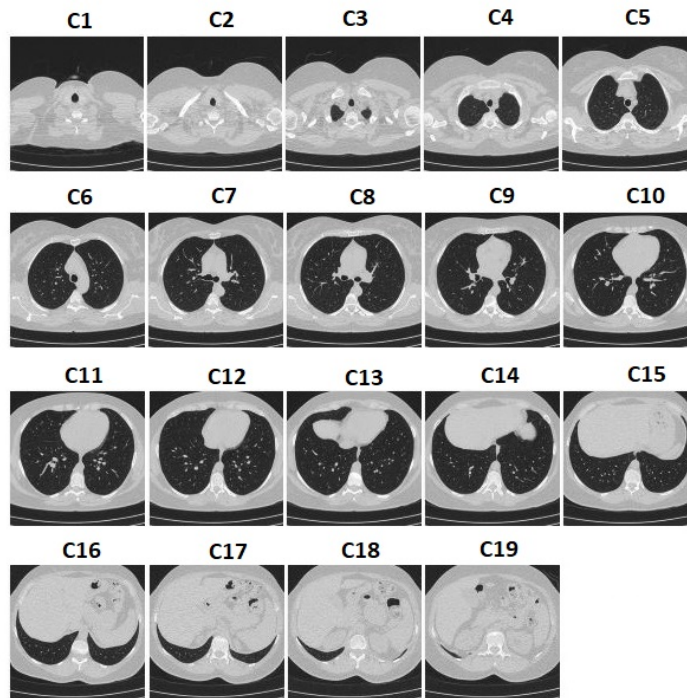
Sample images from each class of EXACT09-CT dataset.
